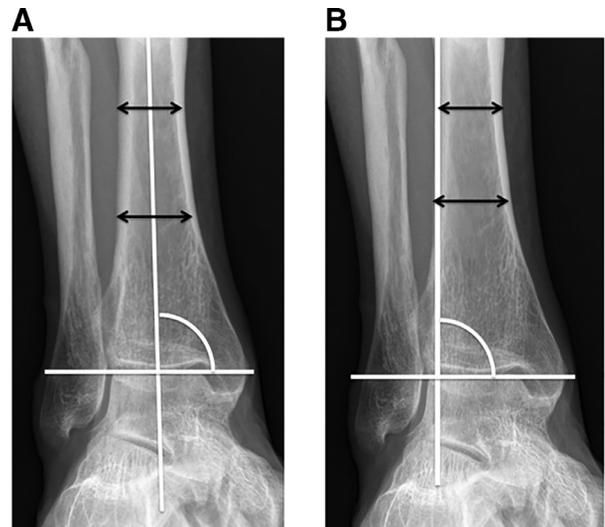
(A) Ankle mortise radiograph with measurement of MTTA. The center points of the medial and lateral margins of the diaphysis of the tibia were plotted at 2 points of the diaphysis. A line was drawn connecting these 2 points, and this was called the anatomical axis of the tibia. A separate line was drawn along the top of the articular surface of the talus. The medial angle was calculated to give the MTTA. (B) Ankle mortise radiograph with measurement of LTTA. Two points of the diaphysis were plotted along the lateral border of the tibia. A line was drawn connecting these 2 points. A separate line was drawn along the top of the articular surface of the talus. The medial angle was calculated to give the LTTA.
